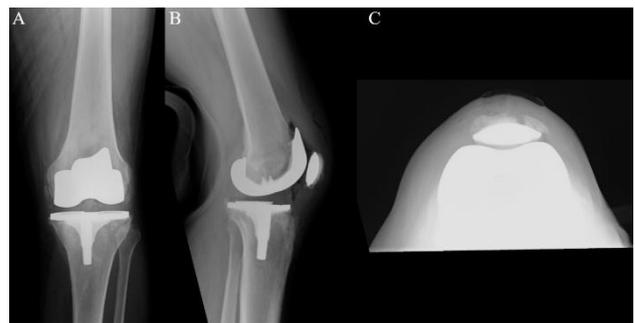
(A) AP, (B) lateral, and (C) sunrise radiographs obtained immediately after patelloplasty.
